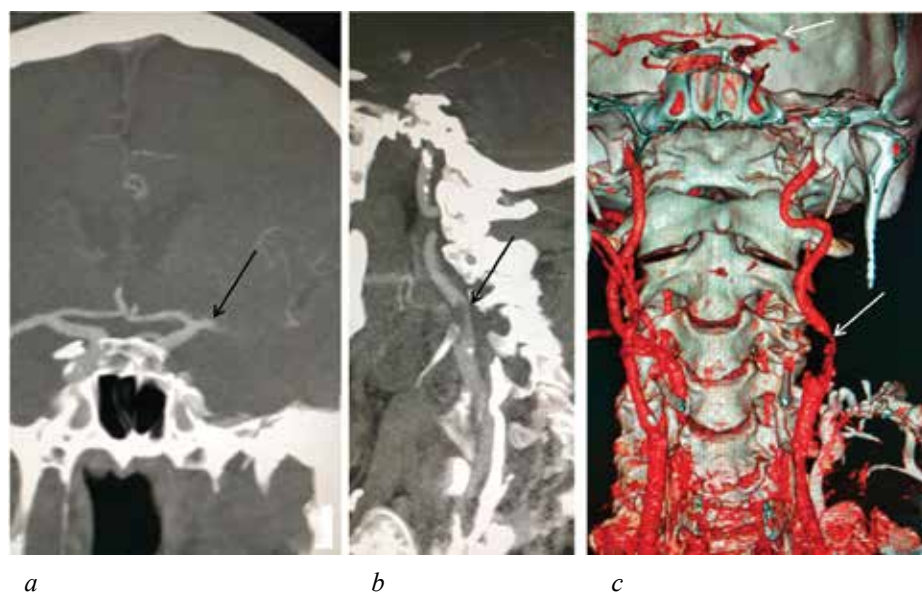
CT angiogram upon admission: occlusion of the M1 segment of the middle cerebral artery (arrow, *a*); clot in the internal carotid artery (arrow, *b*); 3D reconstruction, occlusion of the M1 segment of the middle cerebral artery and clot in the internal carotid artery (arrows, *c*)
